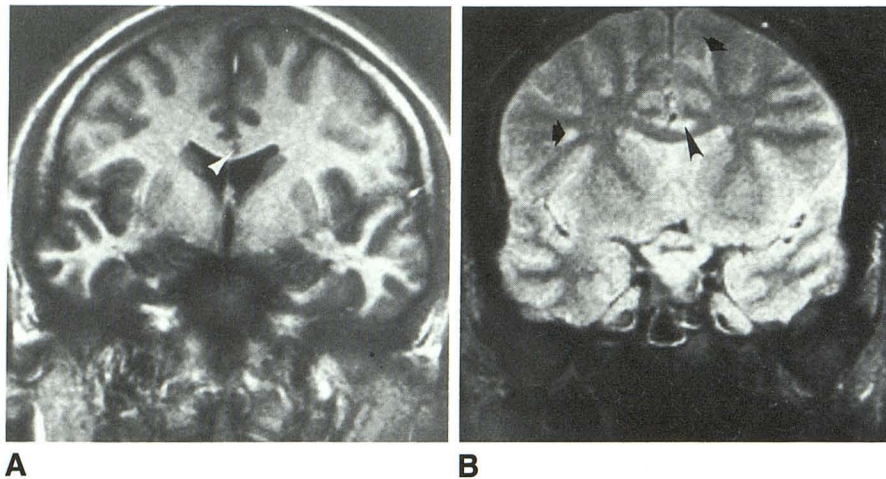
Coronal T1-weighted IR, 2000/500 (A), and T2-weighted SE, 2300/80 (B), images reveal minimal tear of superior aspect of body of corpus callosum near midline (arrowheads). Lesion does not extend through full thickness of corpus callosum. This nonhemorrhagic lesion (arrowheads) is hypointense on T1-weighted and hyperintense on T2-weighted images. Also evident are multiple other nonhemorrhagic diffuse axonal injury lesions (arrows) in cerebral white matter. Diffuse axonal injury lesions commonly occur in association with corpus callosum injuries.
